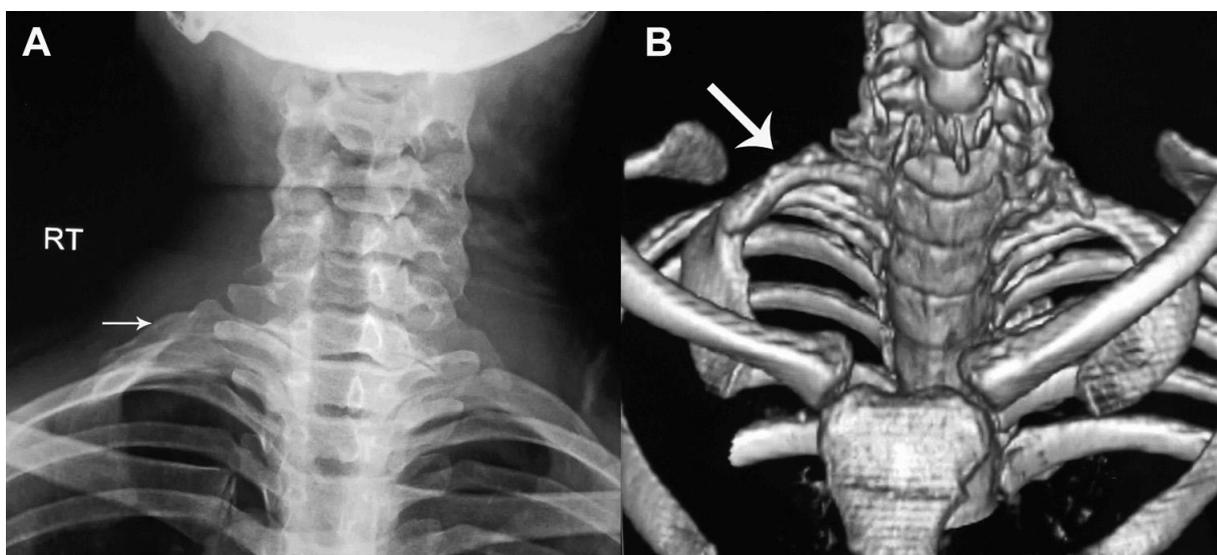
An 22 year-old woman with right brachial radiculopathy. (A) The plain x-ray showing a complete cervical rib (arrow). (B) Three-dimensional computed tomography scan showing a complete cervical rib fused with the first rib (arrow).
